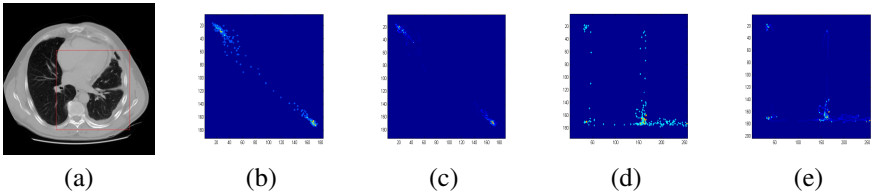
Exp. II: a) Thoracic CT slice of a MPM patient; Region of interest outlined in red b),c) Histogram estimate of adjoining and separate scanlines, respectively; d), e)NPW estimate of the same scanline pairs)
